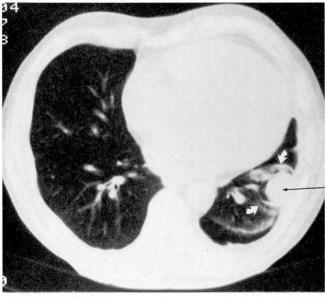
Two versions of the same CT scan through the lower chest in a 64-year-old man with a history of asbestos exposure. In the top photograph, note the 2.5-cm soft tissue lesion in the left lower lobe (long white arrow) adjacent to an area of pleural thickening (short black arrows), displaying the characteristics of a rounded atelectasis, or atelectatic pseudotumor. In the above photograph, vessels and bronchi (curved arrows) are seen converging toward the lesion (note comet-like appearance).
